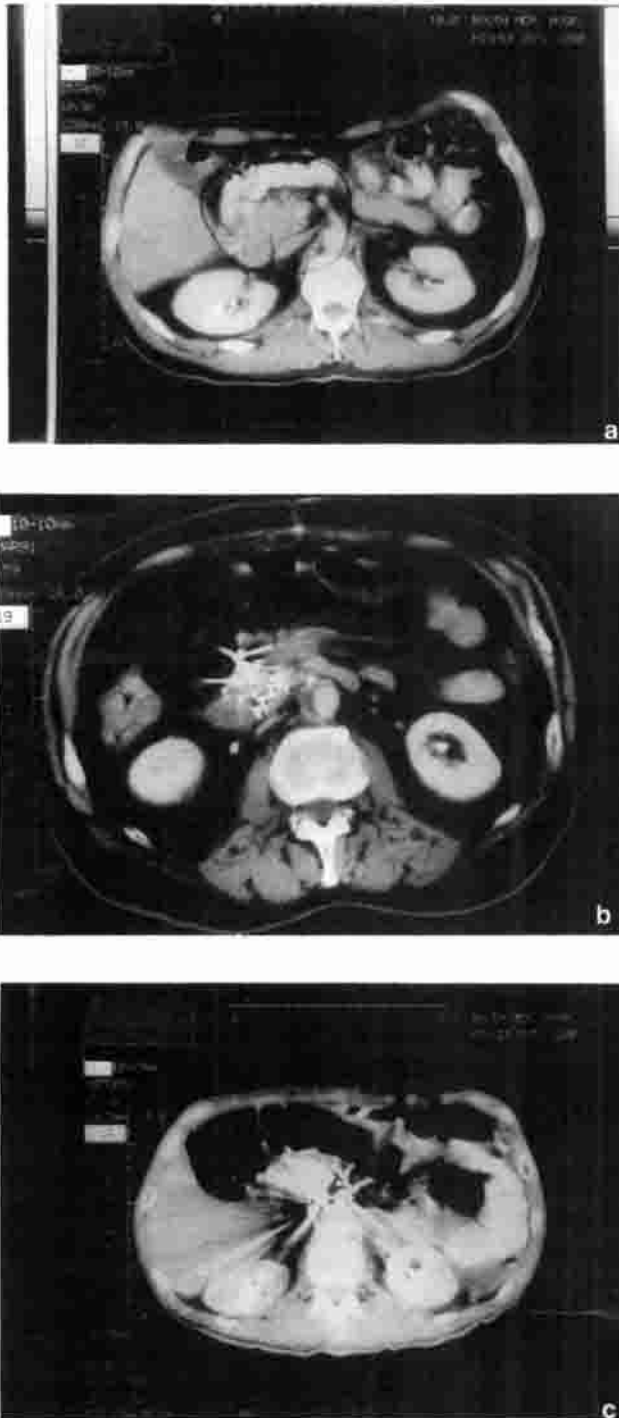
a: CT scan of the abdomen showing a pancreatic head lesion in a 51-year-old patient. b: CT scan of the abdomen of the same patient showing Pd-103 radioactive sources uniformly distributed in the head of the pancreas, sparing the duodenum. c: At the 24-month follow-up, a CT scan of the abdomen is shown with no progression of local disease. The patient died of distant metastases in the lung and neck.
